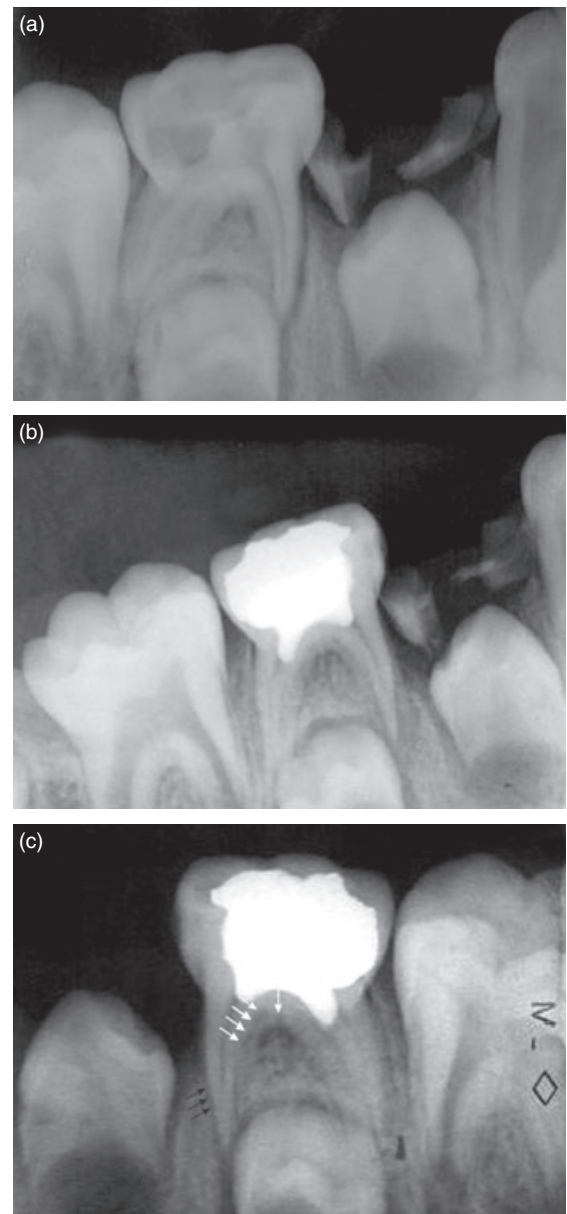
(a) Initial radiographic feature of failure in pulpotomy with formocresol. (b) Radiographic feature of failure in pulpotomy with formocresol after 3 months. (c) Radiographic feature of failure in pulpotomy with formocresol after 6 months. Note the resorption in dentine (white arrows) and thinning of the mesial root of the teeth (black arrows).
